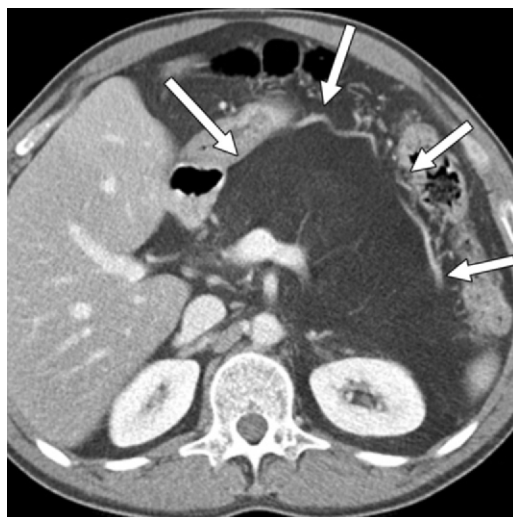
Pancreatic lipomatosis in a 23-year-old man with cystic fibrosis. Axial contrast-enhanced CT image shows expansion and complete replacement of the pancreas with lipomatous tissue (arrows).
